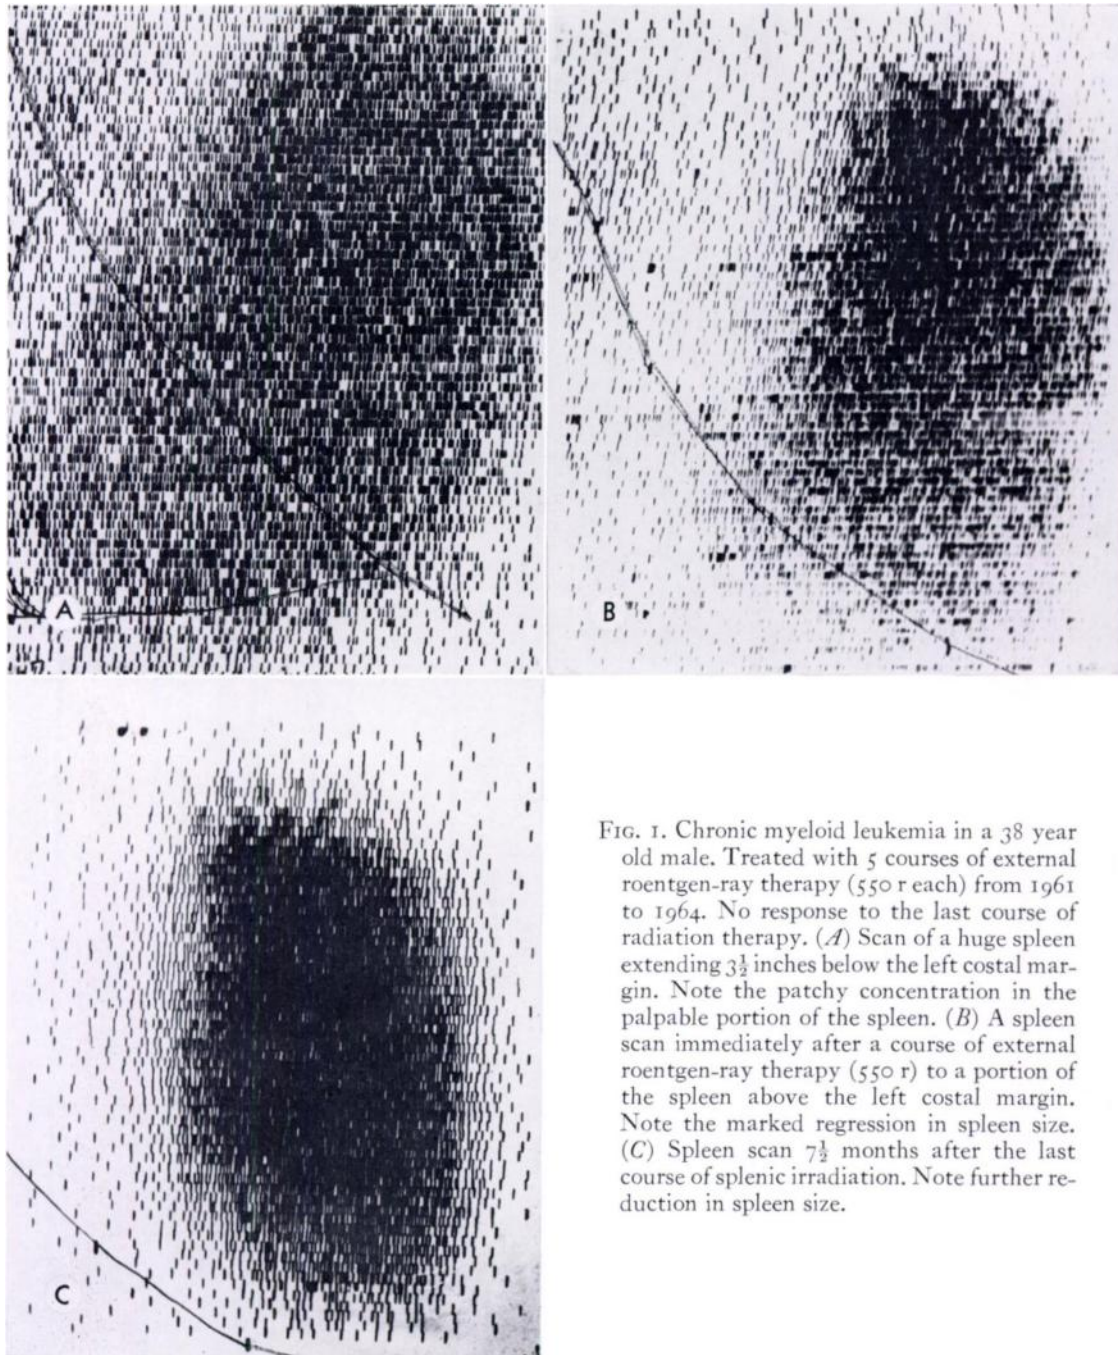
Chronic myeloid leukemia in a 38 year old male. Treated with 5 courses of external roentgen-ray therapy (550 r each) from 1961 to 1964. No response to the last course of radiation therapy. (A) Scan of a huge spleen extending $3\frac{1}{2}$ inches below the left costal margin. Note the patchy concentration in the palpable portion of the spleen. (B) A spleen scan immediately after a course of external roentgen-ray therapy (550 r) to a portion of the spleen above the left costal margin. Note the marked regression in spleen size. (C) Spleen scan $7\frac{1}{2}$ months after the last course of splenic irradiation. Note further reduction in spleen size.
